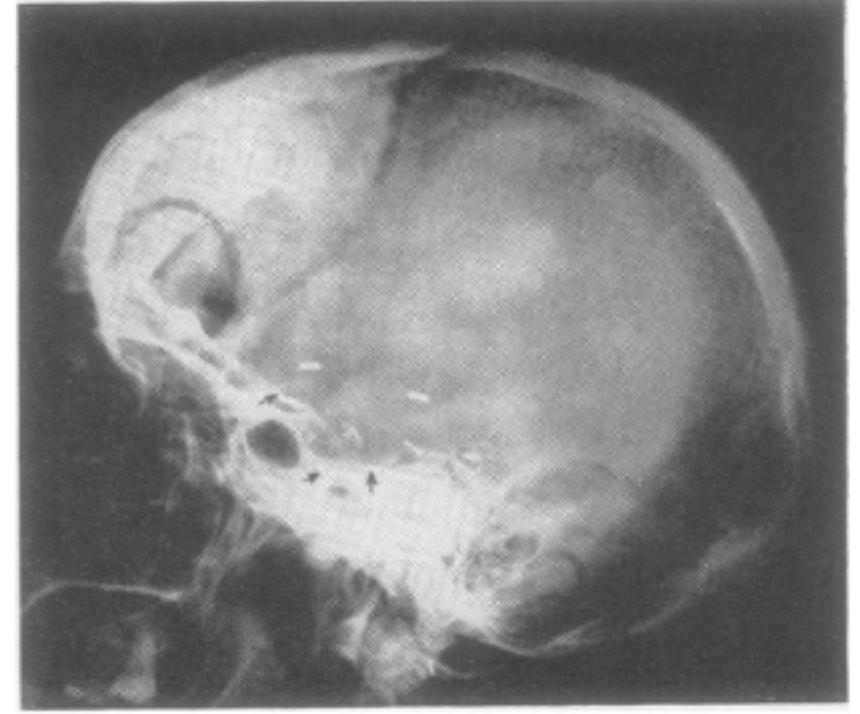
Post-operative skull radiograph with silver clip markers outlining the extent of the bilateral resections including the anterior hippocampal complex (approximately 6 cm. posterior to the tip of the anterior temporal fossa).
